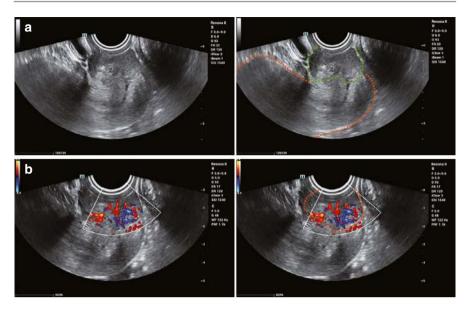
(a) B-mode ultrasound shows a hypoechoic mass at the external cervical os (exophytic type) with poorly defined borders and irregular morphology. The structure of the cervical canal remains intact. The uterus and cervix are circled in orange; the tumor is circled in green. (b) Color Doppler ultrasound demonstrates abnormally abundant and branching blood flow signals within the cervical cancer. The tumor is circled in orange
